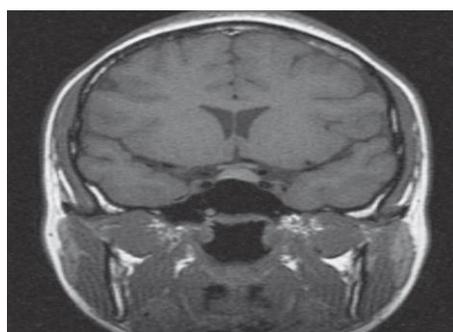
MRI scan of the head.
